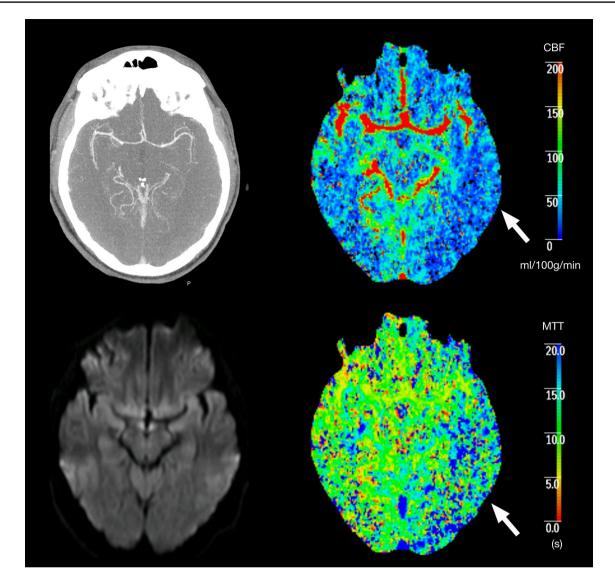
Acute CT angiography (top left) showing absence of vascular occlusion, concomitant cerebral blood flow (top right) and mean transit time (bottom righ) maps displaying a focal area of hypoperfusion
